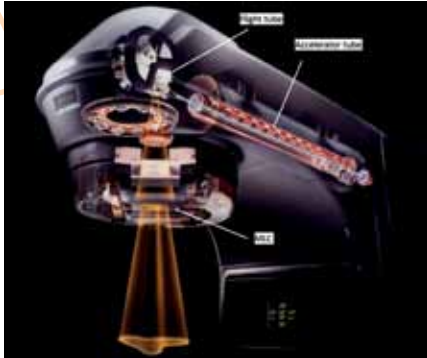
Inside a medical accelerator. Electrons are accelerated in the accelerator tube from right to left and smash into a high-Z material, producing X-rays (in orange).
